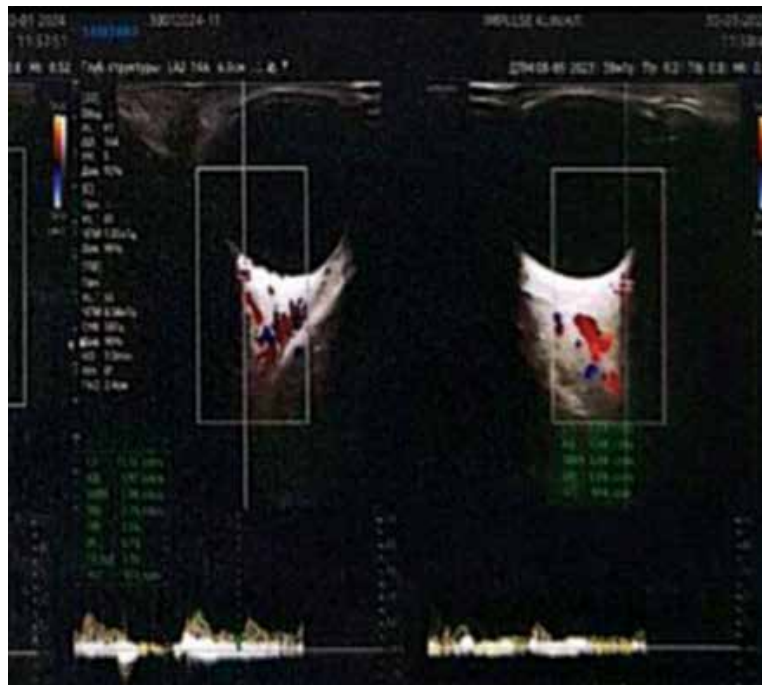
Ultrasound Doppler scan of the ophthalmic artery vascular basin prior to surgery: Right eye - blood flow velocity in the ophthalmic artery was 26.9 cm/s; central retinal artery - 18.9 cm/s; medial short posterior ciliary artery - 8.5 cm/s; lateral short posterior ciliary artery - 10.2 cm/s; Left eye: blood flow velocity in the ophthalmic artery was 25.7 cm/s; central retinal artery - 21.8 cm/s; medial short posterior ciliary artery - 13.0 cm/s; lateral short posterior ciliary artery was 14.7 cm/s.
